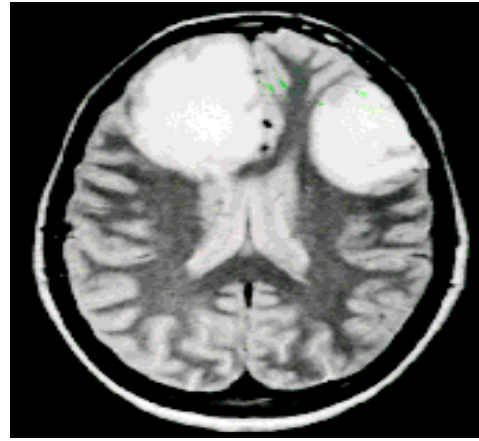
Brain magnetic resonance image showing 2 rounded lesions in both frontal lobes, with surrounding edema and minimal mass effect.
